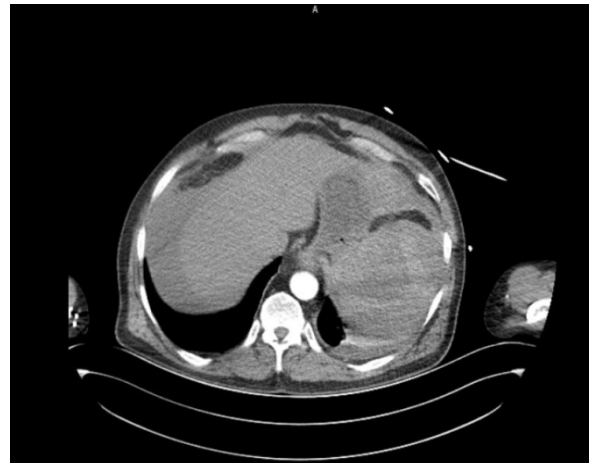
Contrast-enhanced abdominal CT
